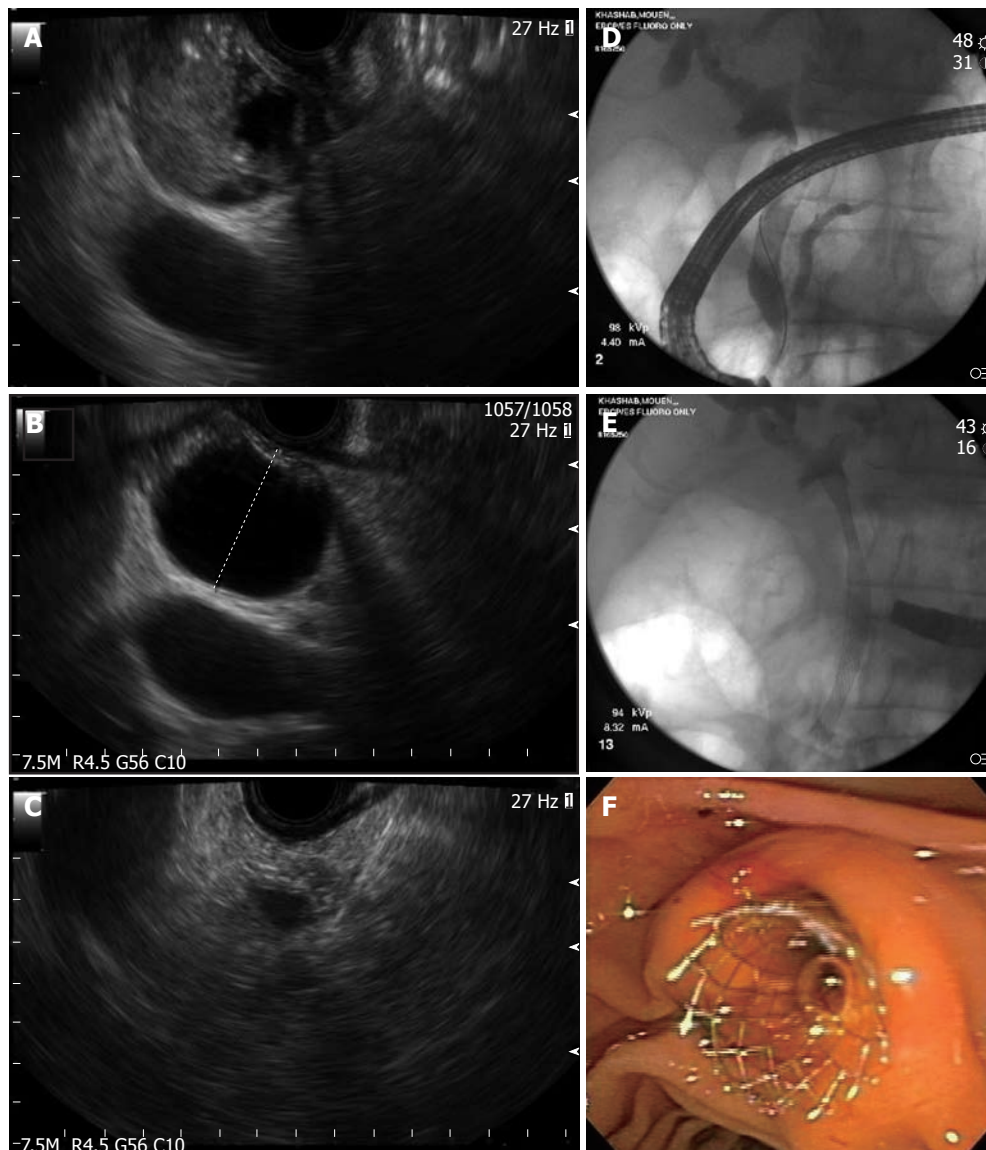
Endoscopic diagnosis and therapy for a bile duct mass missed on transabdominal imaging. A: Endoscopic ultrasound showing a bile duct mass that was missed by computed tomography and magnetic resonance imaging; B: Biliary dilation was present proximal to the stenosis; C: Endoscopic ultrasound-guided fine needle aspiration was performed and was diagnostic of cholangiocarcinoma; D: Endoscopic retrograde cholangioscopy was performed during the same session and cholangiography revealed distal biliary stricture; E, F: A fully-covered metal biliary stent was placed.
